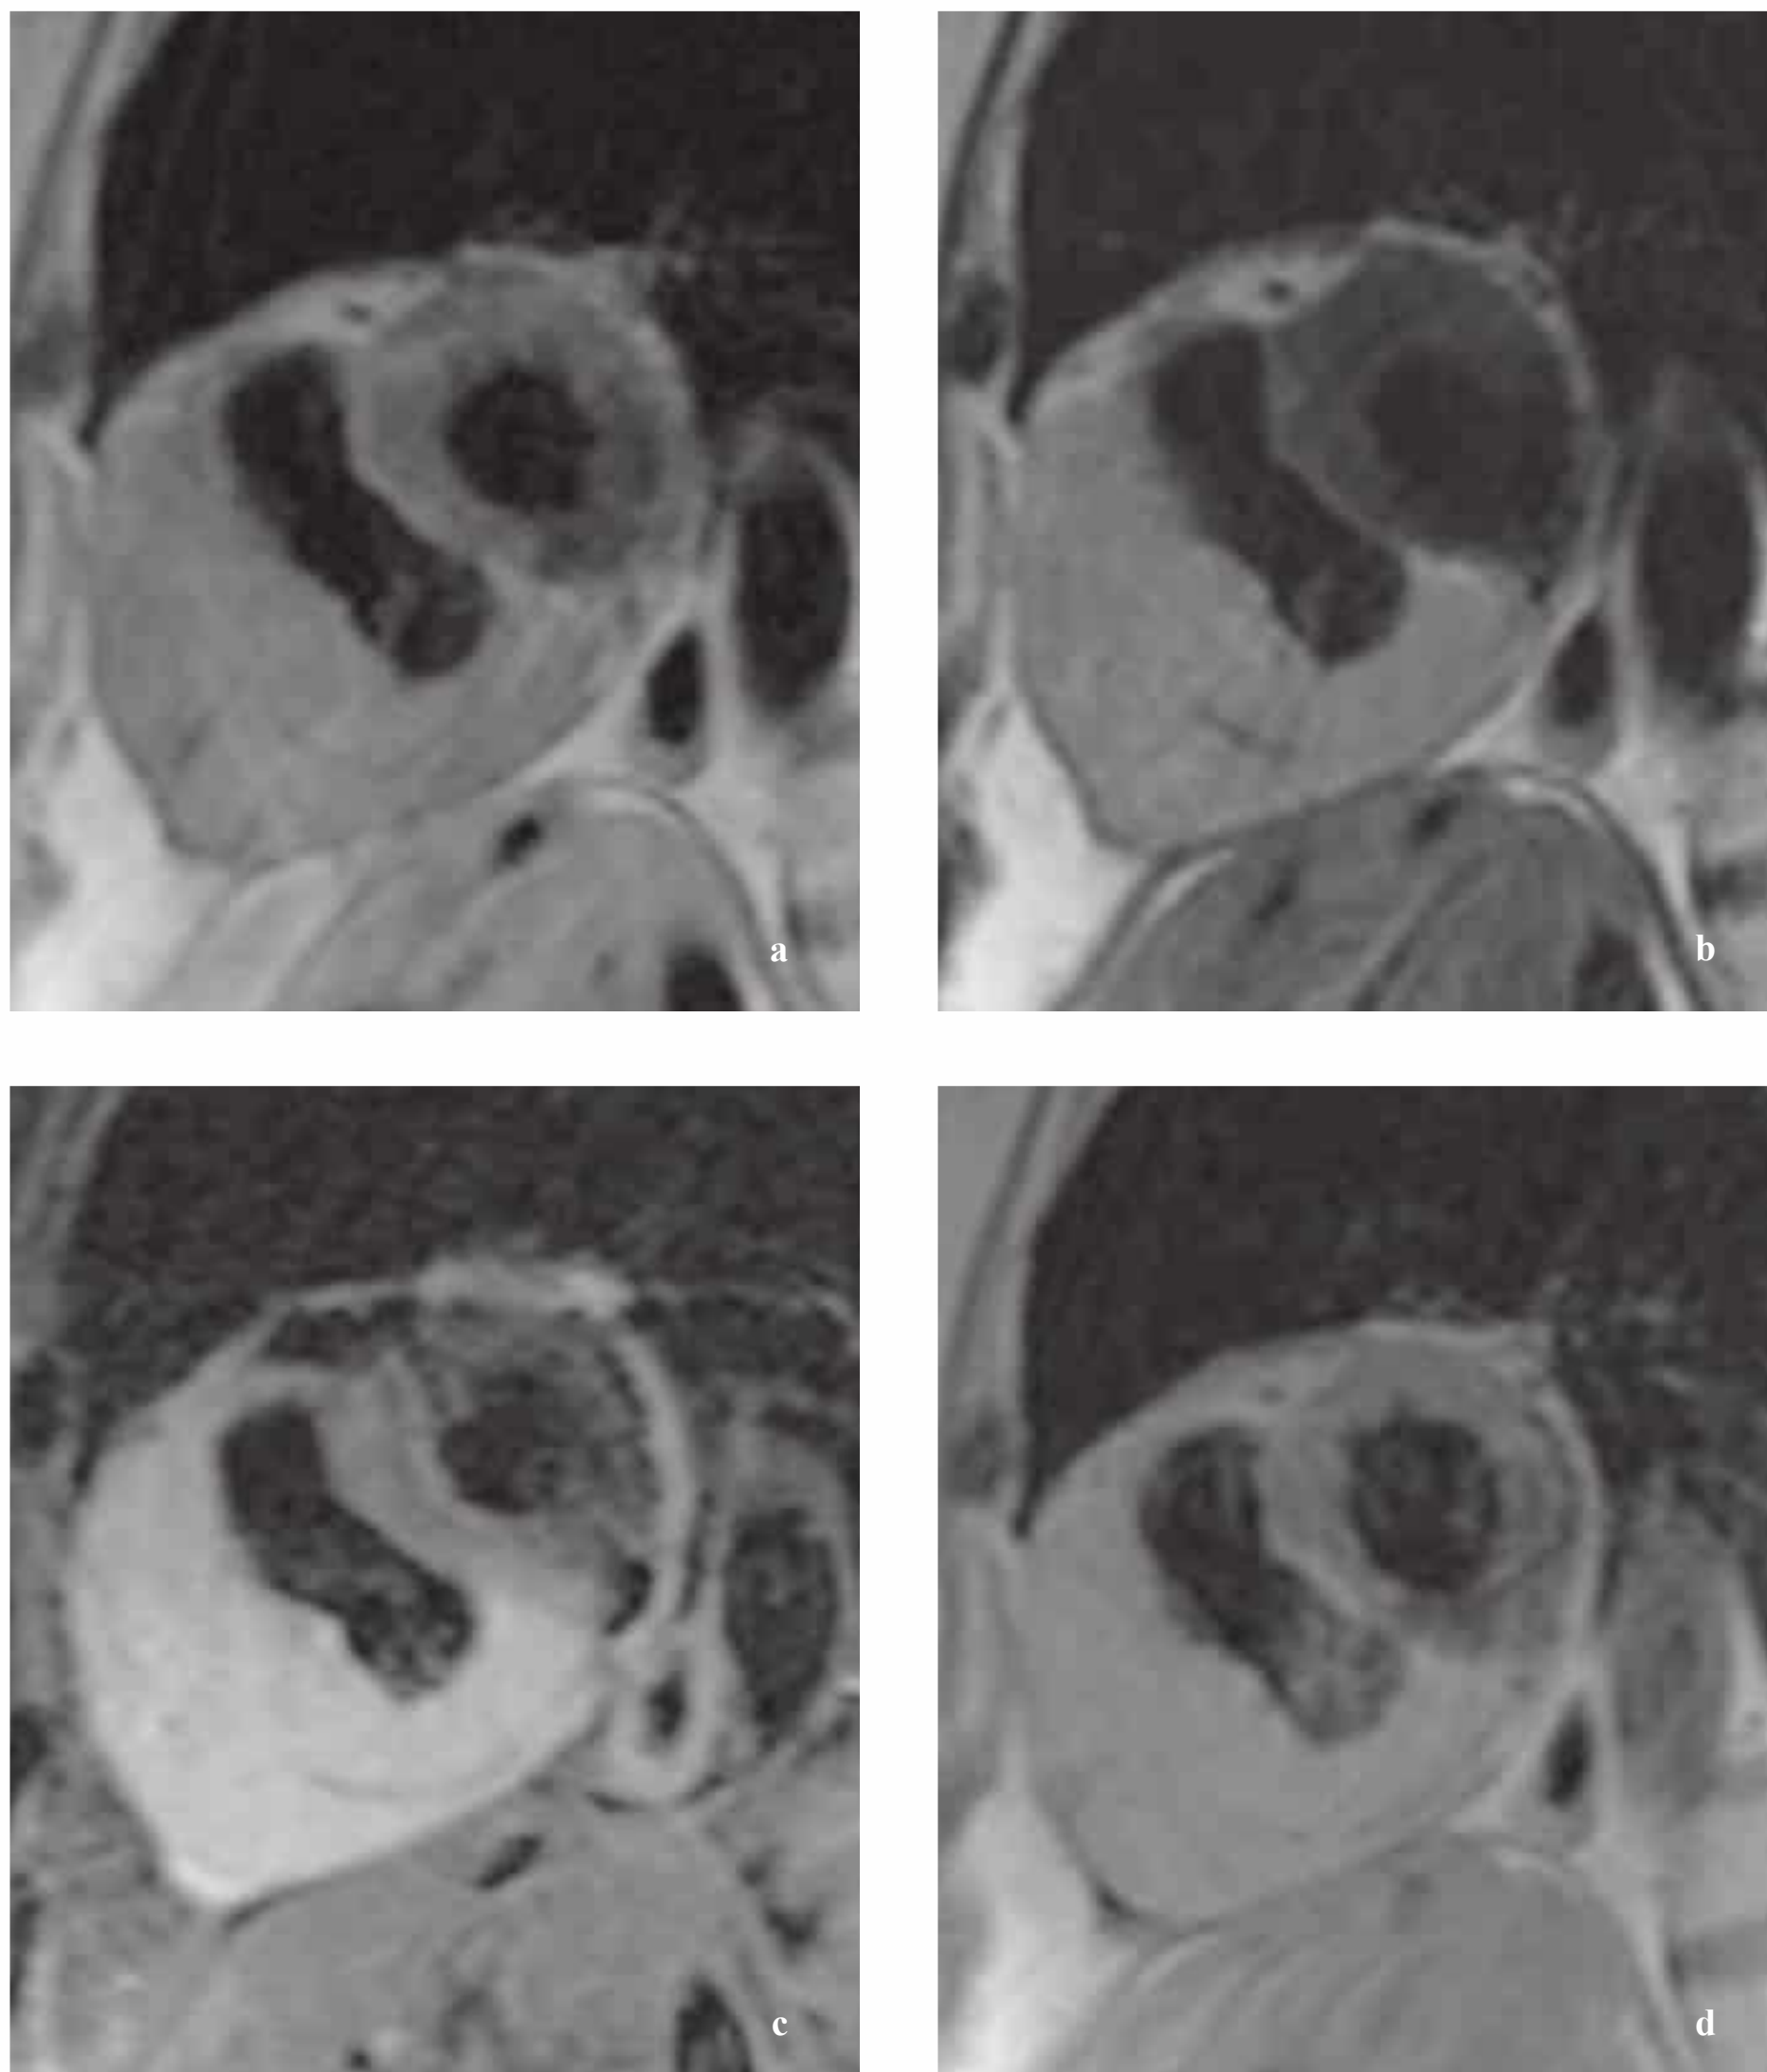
a–d Short-axis views in a patient with intrapericardial lymphoma. T1-weighted (a) and T2-weighted (b) dark-blood TSE images and a T2-weighted sequence with fat saturation (c). All the sequences show a homogeneous, well-circumscribed mass compressing the right ventricle. The T1-weighted image after contrast administration (d) shows homogeneous enhancement.
